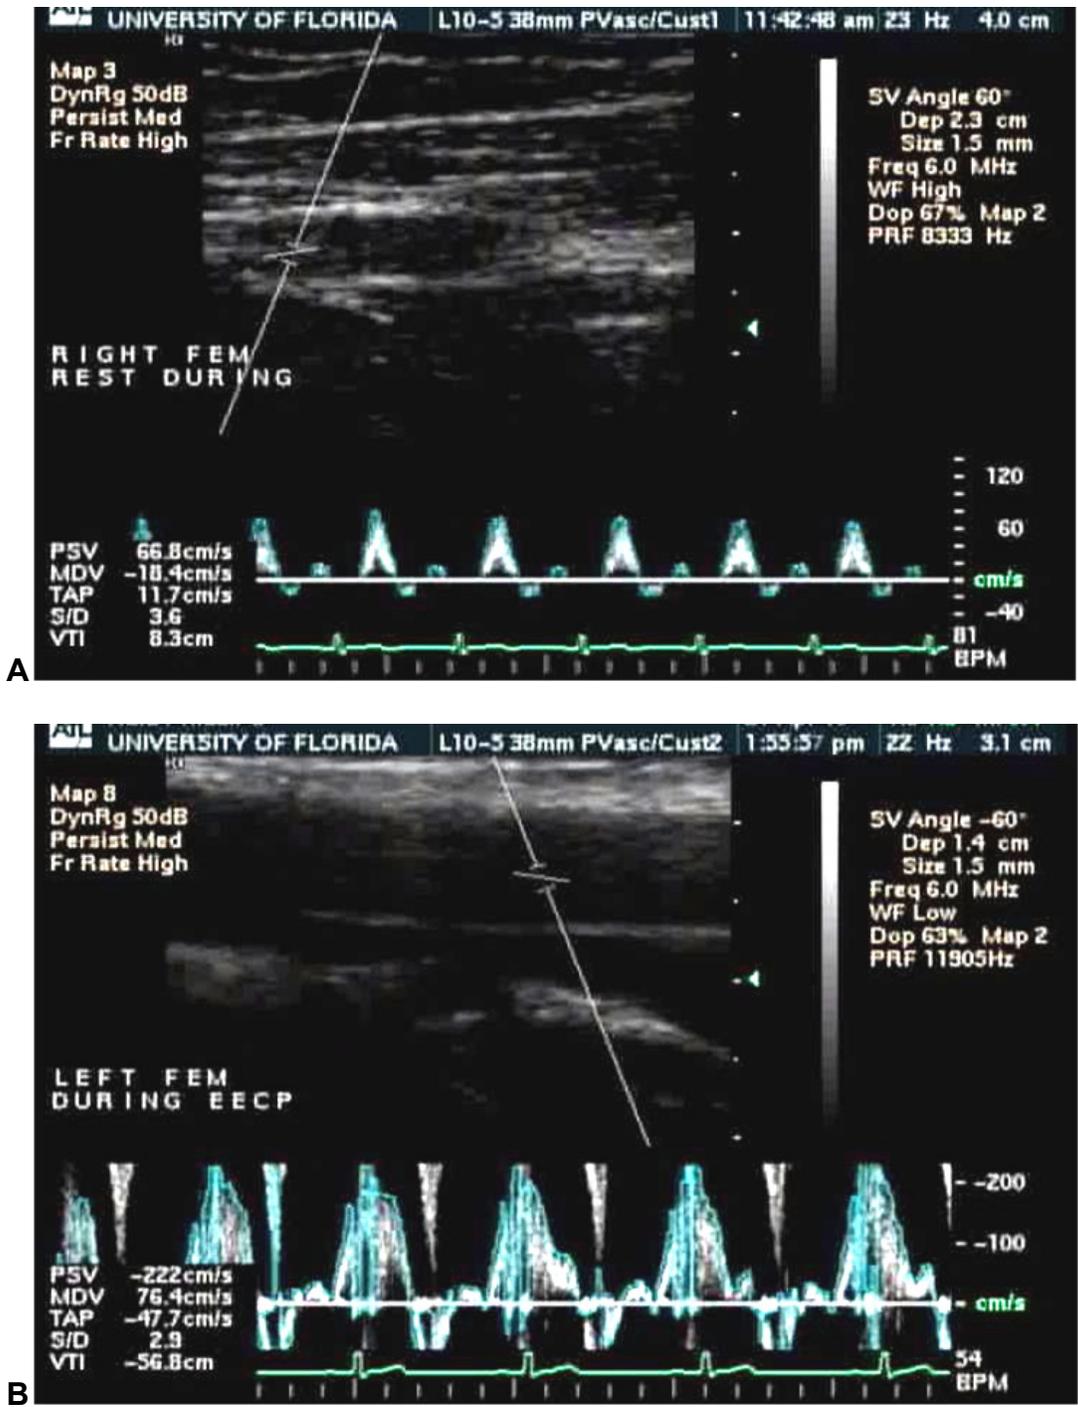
High definition ultrasound pictures and Doppler spectrum of the femoral artery during sham (A) and EECP (B).
